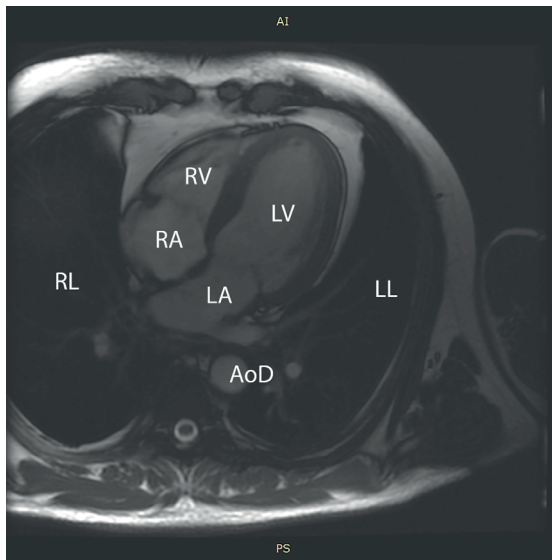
An MRI image of a patient with acute myocardial infarction. The compartments of a human heart are depicted. Abbreviations: RL: right lung, LL: left lung, RV: right ventricle, LV: left ventricle, RA: right atrium, LA: left atrium, AoD: descending aorta.
